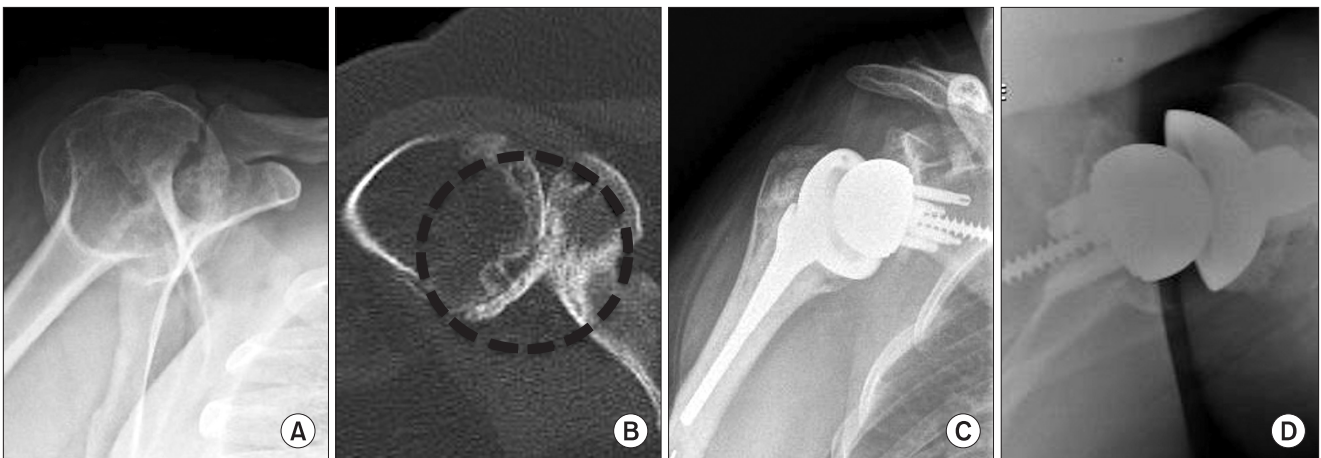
A 44-year-old female patient with glenoid dysplasia. (A) Preoperative conventional anteroposterior radiograph of the shoulder showing the altered glenoid anatomy, consistent with dysplasia. (B) Preoperative computed tomography scan, axial cut shows narrowed joint space and severely distorted articular surfaces of head and glenoid (dotted circle). Conventional radiographs of the shoulder at 6 months' follow-up show a well-fixed prosthesis: (C) anteroposterior view, and (D) axillary view.
